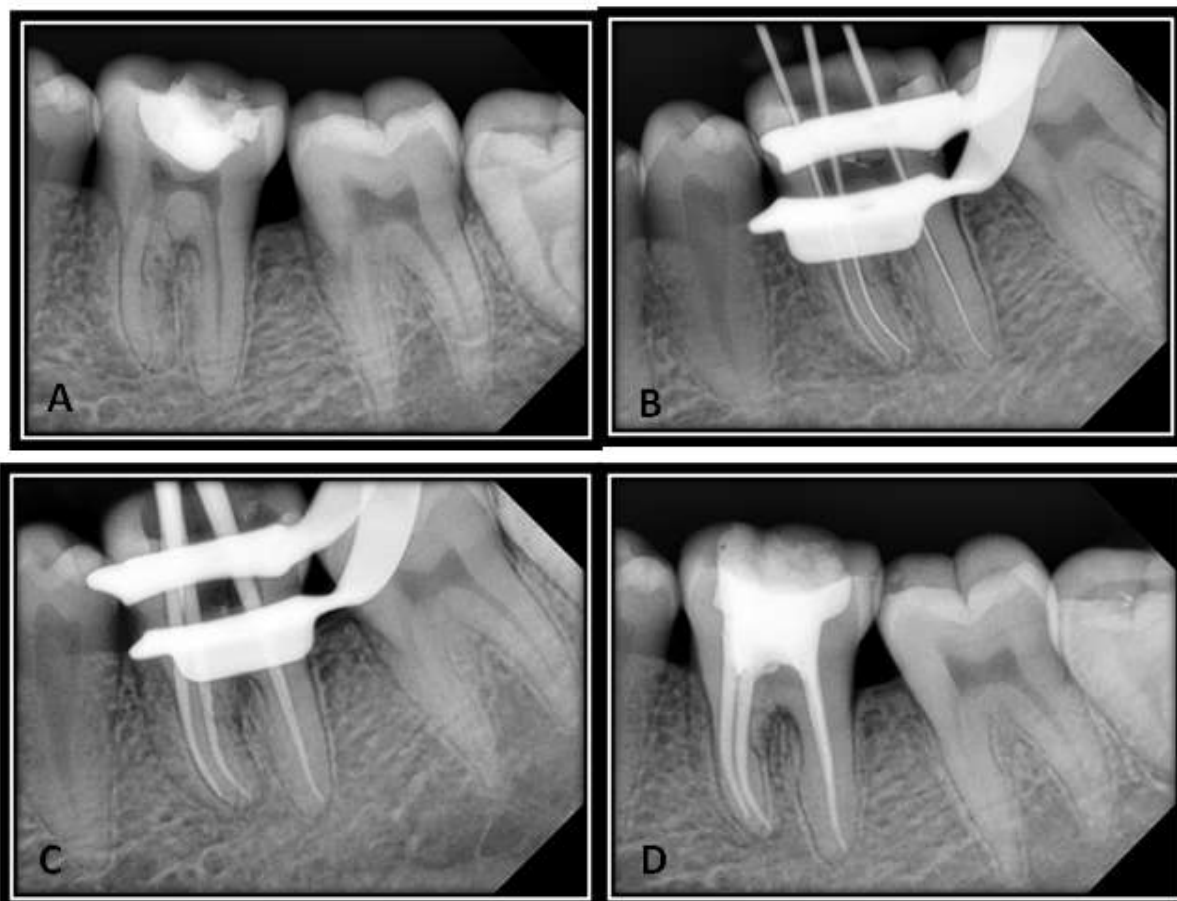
(a) Pre-operative radiograph, (b) working length determination, (c) gutta-percha cone fit, (d) post-operative radiograph
